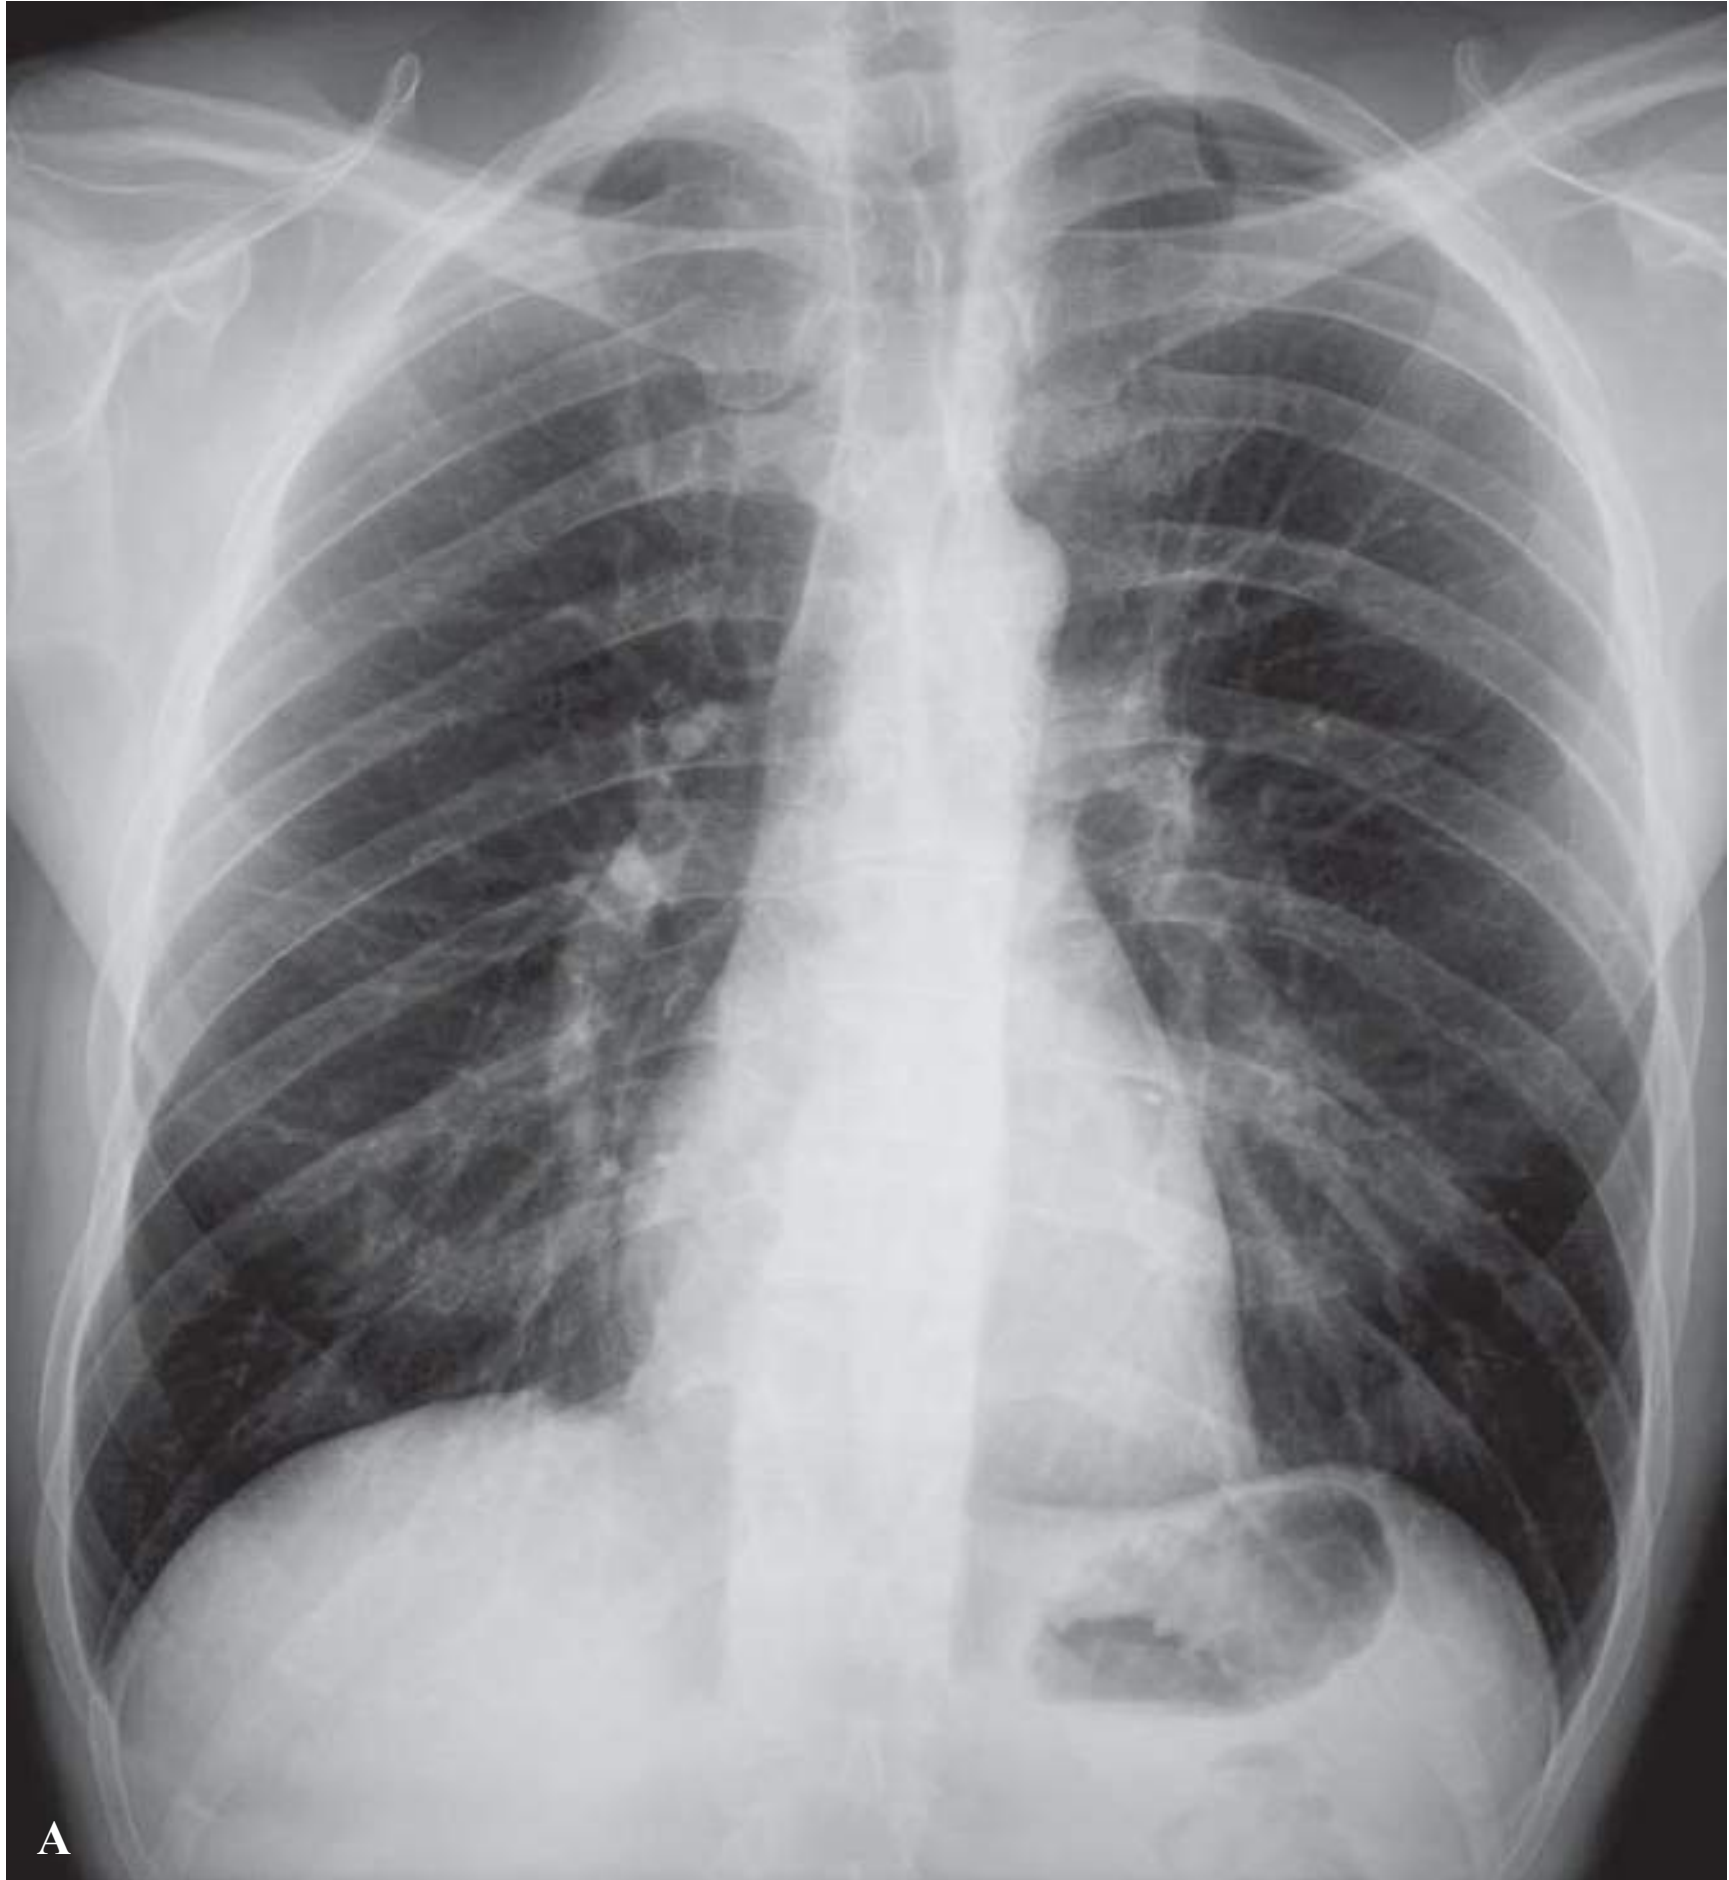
Radiographic appearances in the normal lung and in emphysema.
